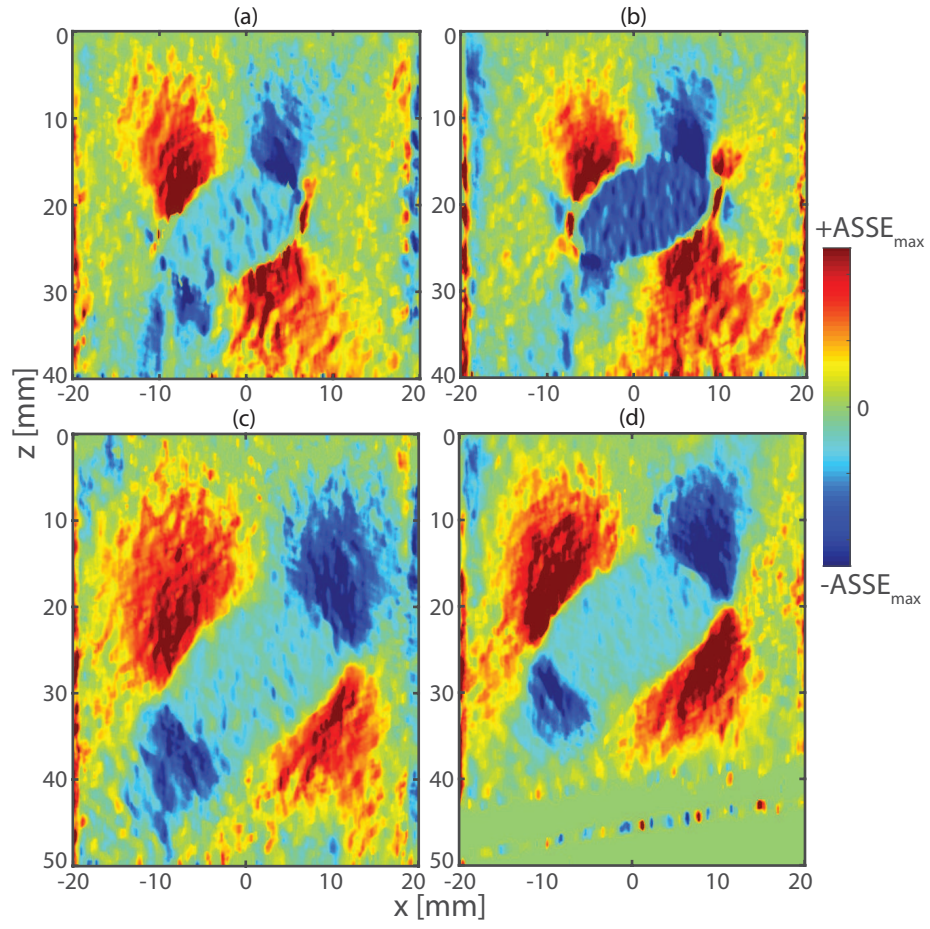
Experimental ASSE images for extremes ultrasound probe angles ($\alpha = 0$ and 6°) of the results shown in 2(b). (a,b) Inclined ($\theta \approx 45^\circ$) loosely bounded inclusion. (c,d) Inclined ($\theta \approx 45^\circ$) firmly bounded inclusion (lack of false fill-in).
